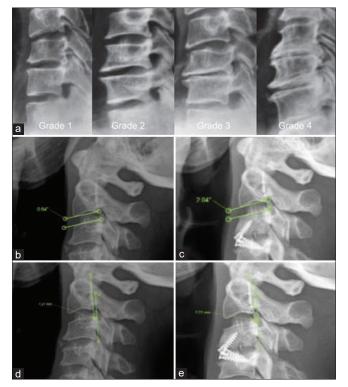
(a) Kellgren–Lawrence classification for grading disc degeneration. (b) Preoperative cervical spine X-ray profile showing the measurement of the angle of the proximal intervertebral disc (0.64°). (c) Postoperative cervical spine X-ray profile showing the measurement of the angle of the proximal intervertebral disc (2.04°). (d) Preoperative cervical spine X-ray profile showing vertebral listhesis (1.21 mm). (e) Postoperative cervical spine X-ray profile showing vertebral listhesis (2.21 mm)
